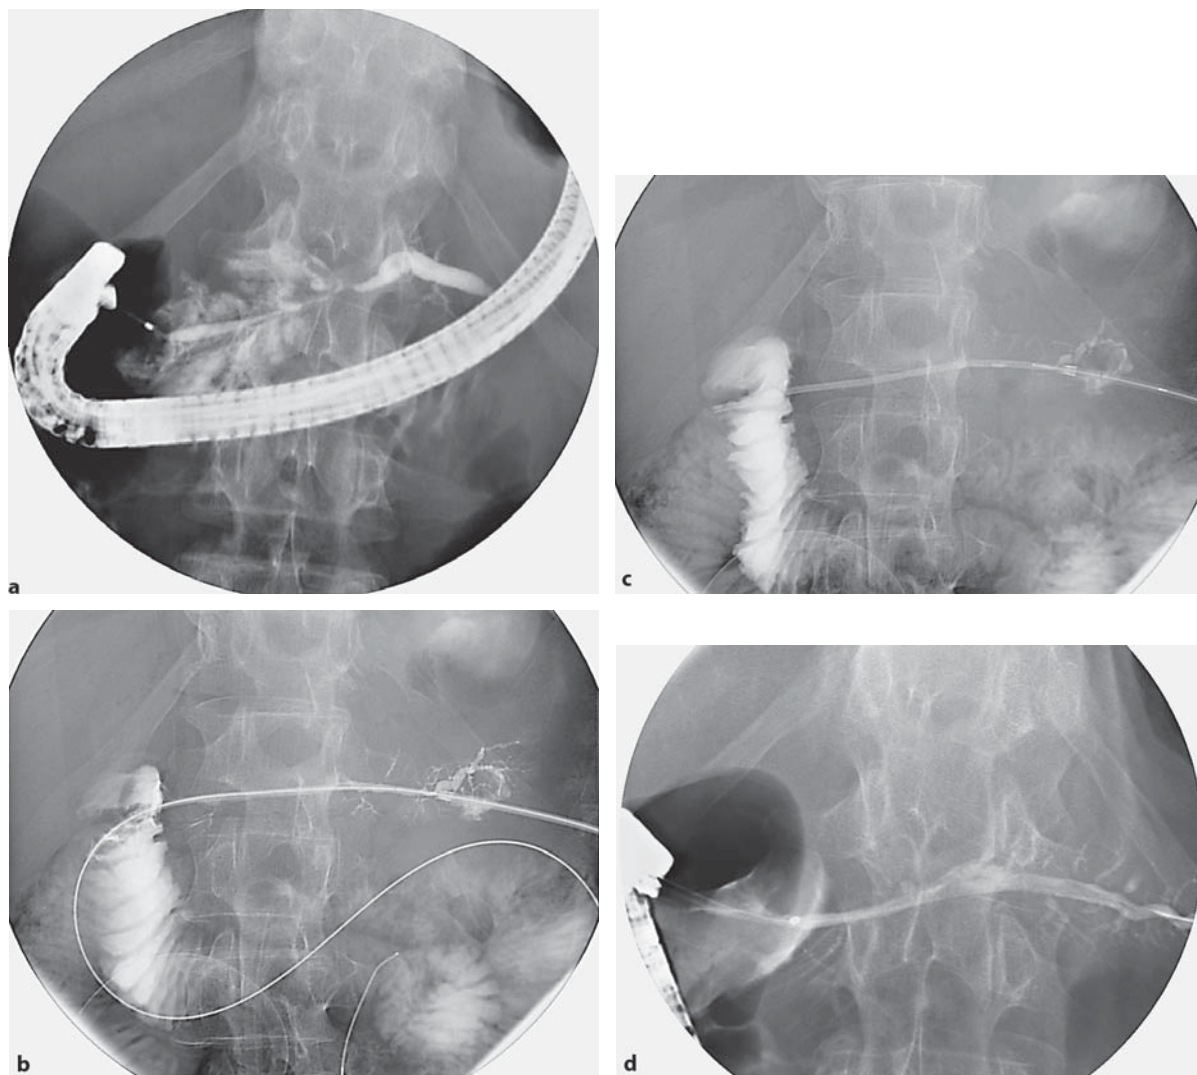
a ERP demonstrating pancreatic duct stricture. b CT-guided needle puncture and injection of the pancreatic duct under fluoroscopy. c A 7-French, 12-cm plastic stent is positioned in the pancreatic duct traversing the stricture and well into the duodenum. d Follow-up ERP after several endoscopic sessions.
